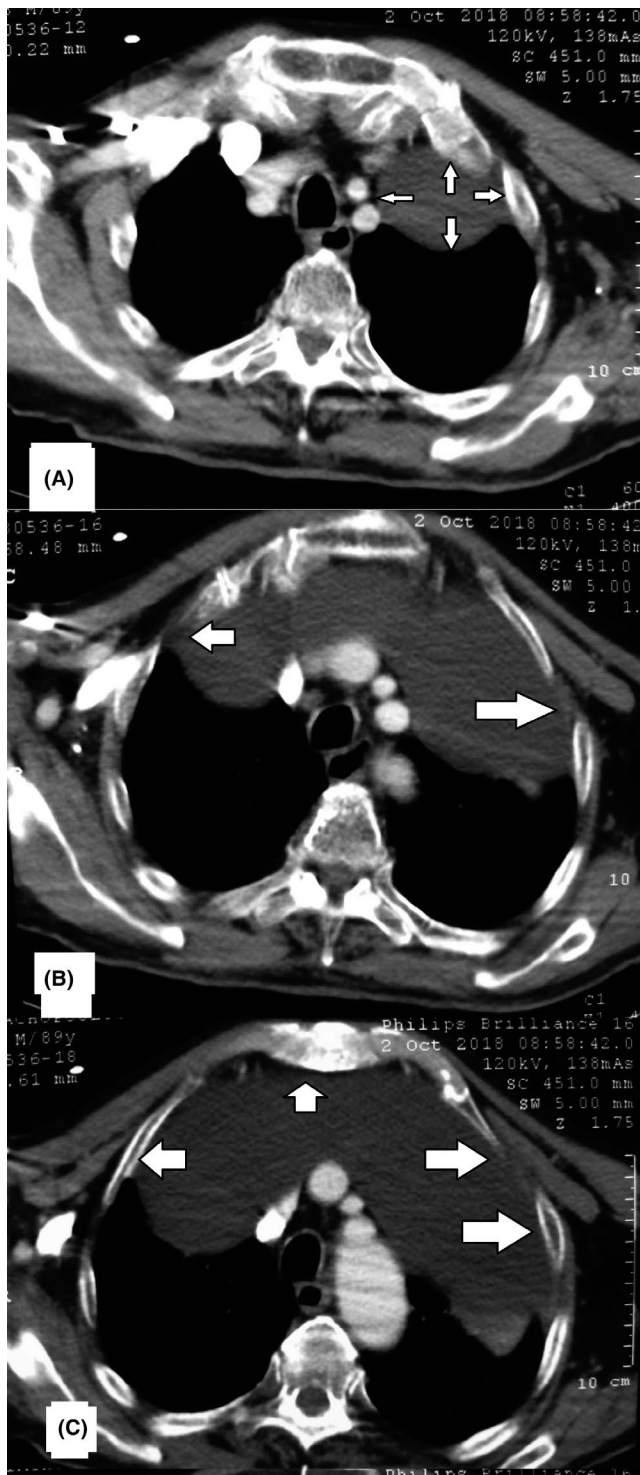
Chest computed tomography (A, B, C). The large mass in the anterior and middle mediastinum with extension in left and right hemithorax (white arrow)
